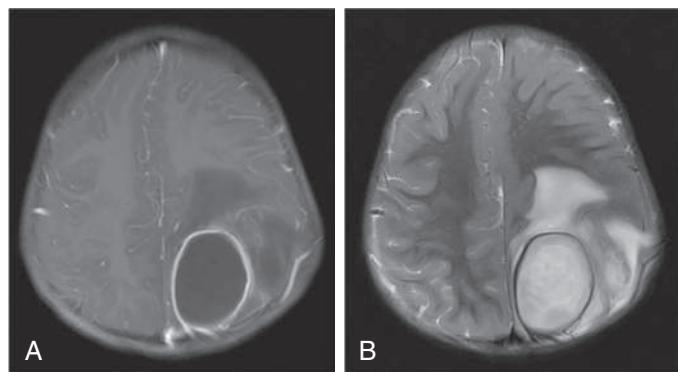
Brain MRI in a 2-yr-old child with an atrial septal defect and brain abscess caused by MRSA. A, T1 fl2D postcontrast axial image demonstrating enhancement of the rim of the abscess. B, T2 TSE axial image showing a large fluid-filled lesion with surrounding edema.
